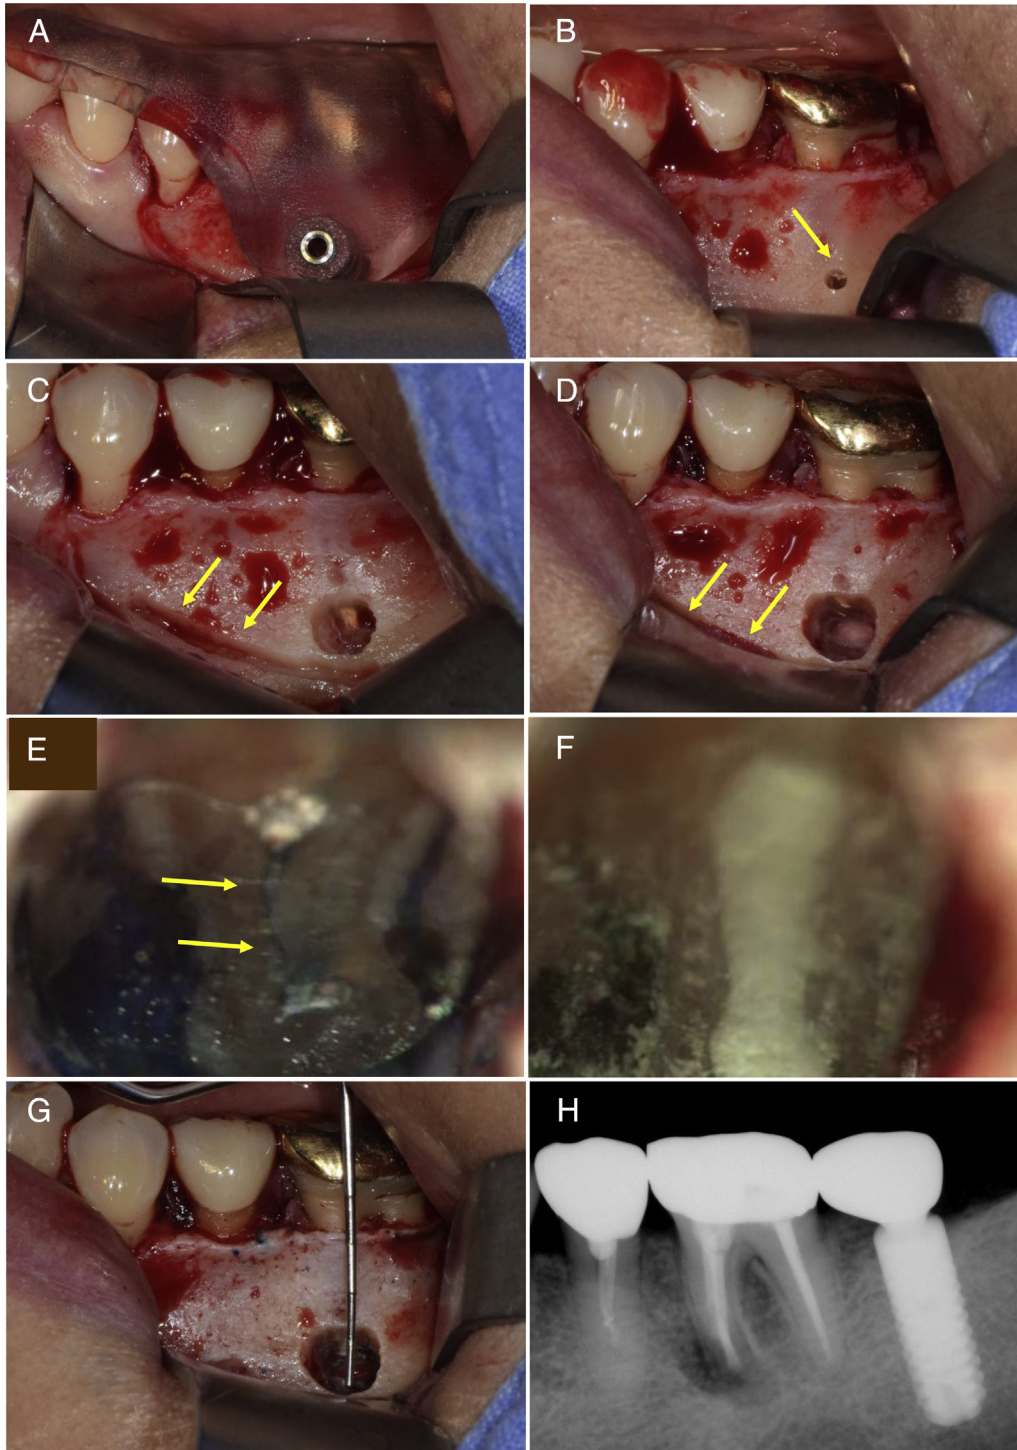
(A) The surgical template was positioned on tooth 19. (B) After drilling using an anchor drill, exposure of the root tip (*yellow arrow*) was confirmed. (C) The bony crypt was enlarged to enable instrument manipulation. A groove (*yellow arrow*) was made on the coronal side of a mental foramen to protect it. (D) The bony crypt after root resection. A KP1 retractor was placed on the groove (*yellow arrow*). (E) The resected root surface inspected under high magnification. The isthmus between the mesiobuccal and mesiolingual canal was inspected (*yellow arrow*). (F) Root-end filling with Retro MTA was confirmed under high magnification. (G) The diameter of the bony crypt after surgery was 4 mm. (H) The postoperative periapical x-ray image.
